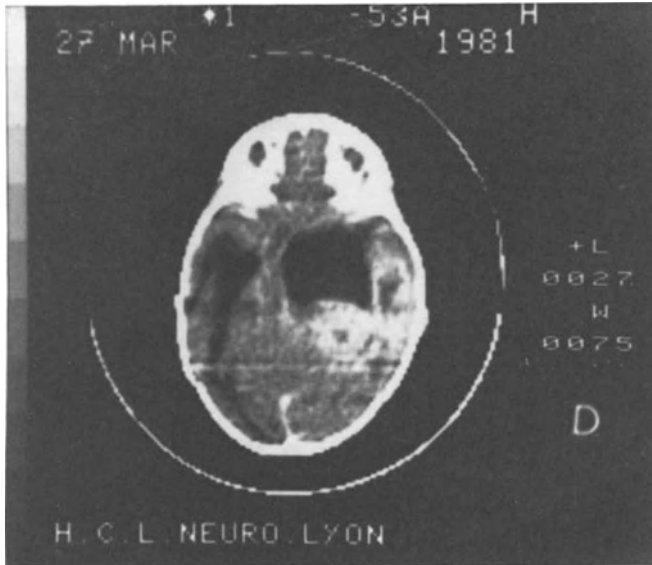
Enhanced CT in an infant with a grade IV ependymoma. Massive dilatation of the right temporal horn with mass effect
